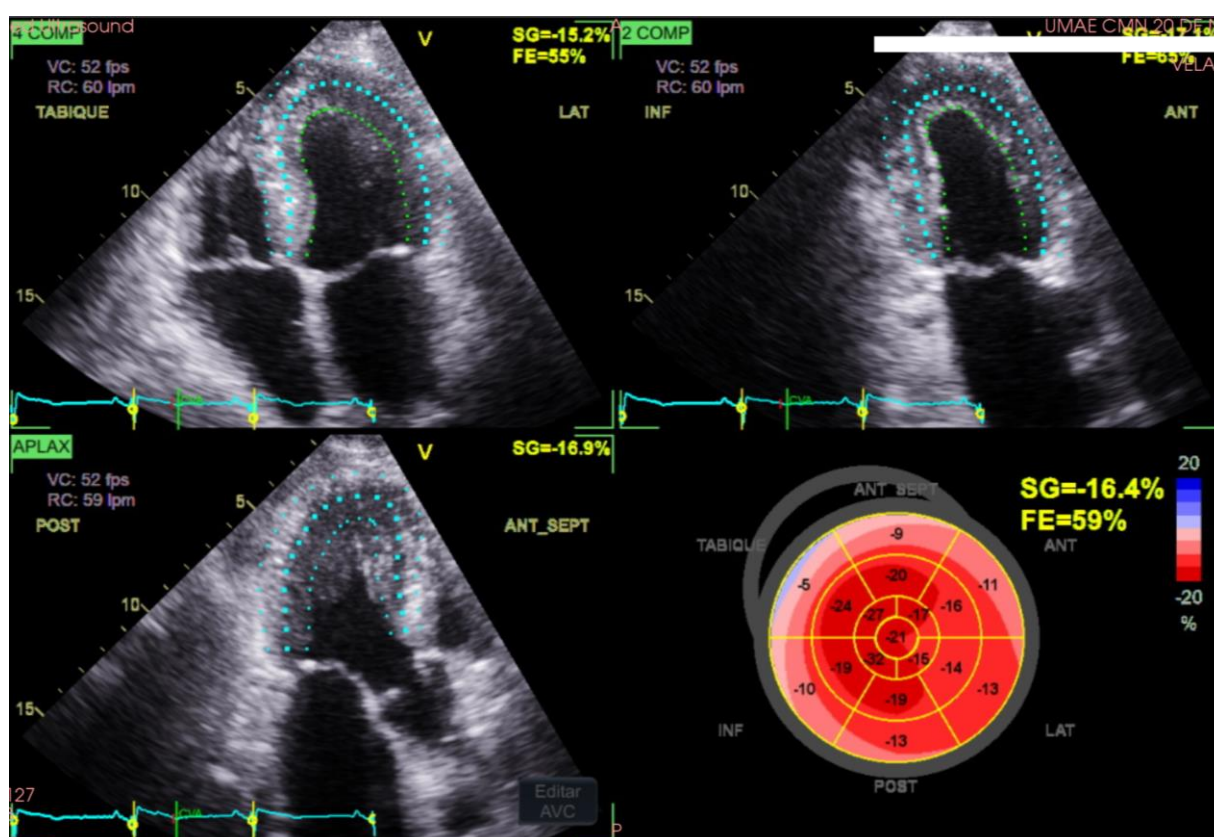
Apical four-chamber, two-chamber, and three-chamber views, to obtain longitudinal tension, show the "cherry-on-top" image, reflecting the decrease in tension at the basal and middle segments. A characteristic pattern of cardiac amyloidosis
